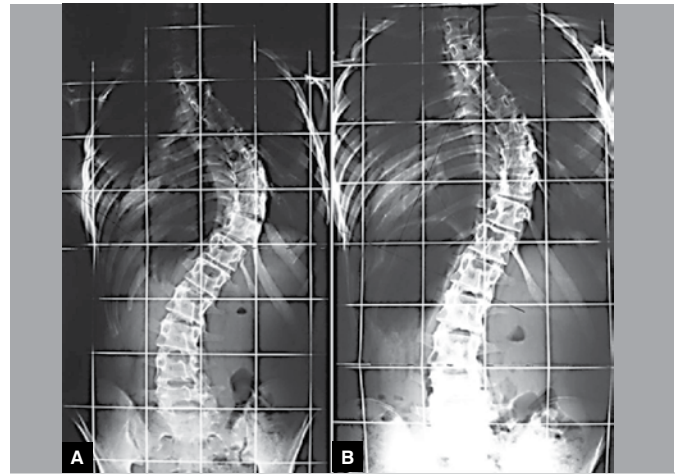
Radiographs of two twin sisters with concordant curve pattern, side and levels of ASV, apex and AIV. A, DM Curve; right/left; ASV T5, apex 9 and AIV T12/ASV L1, apex L4, AIV L5. B, DM Curve; right/left; ASV T5, apex T9, AIV T12/ASV L1, apex L4, AIV L5.
